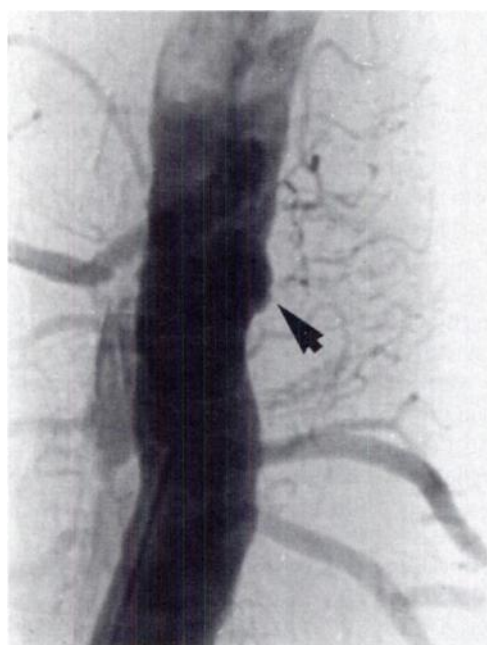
RA thrombosis. (a) Doppler spectrum (left) and sonogram (right) of the segmental arteries of the left kidney show a severe tardus-parvus waveform. (b) Color Doppler sonogram shows that the proximal segment of the left RA is without flow (arrow). (c) Angiogram shows thrombosis of the left RA (arrow).
